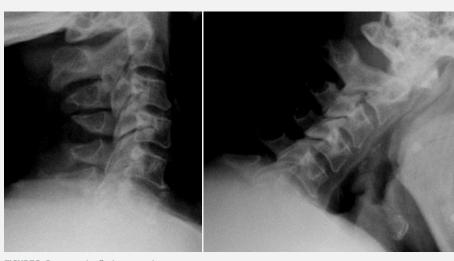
Pre-operative flexion-extension x-rays
